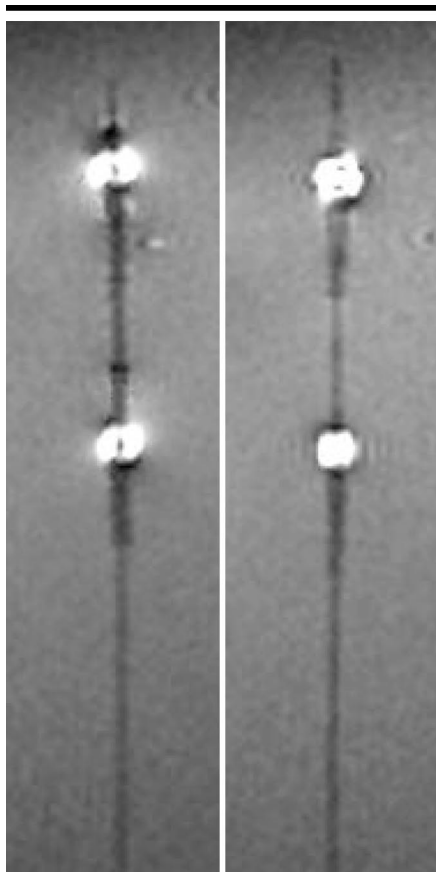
MR images acquired with interactive steady-state free precession (2.9/1.6; flip angle, 45°; section thickness, 8 mm; acquisition frame rate, 8 per second; field of view, 280 mm; matrix, 128 × 128) show SDS with RCs in saline bath. Note the intense signal of the RCs before (left) and after (right) delivery of the nitinol stent.
